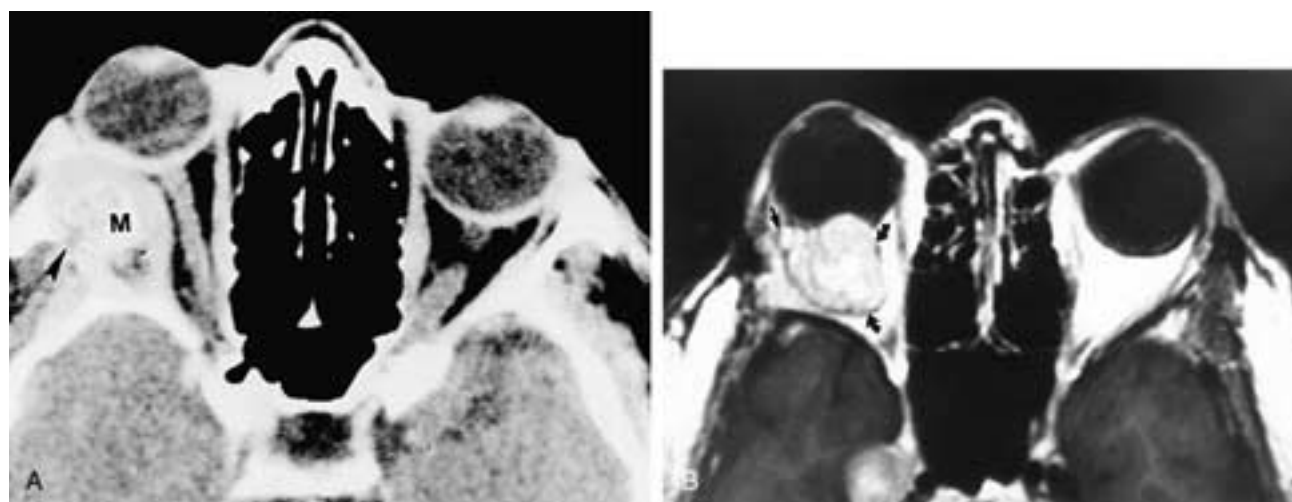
A, Hemangiopericytoma. Contrast-enhanced axial CT scan shows an enhancing mass (*M*) compatible with hemangiopericytoma. Note the erosion of the lateral orbital wall (*arrowhead*). B, Recurrent hemangiopericytoma. Enhanced axial T1-weighted MR scan shows a heterogeneously enhancing mass (*arrows*) compatible with recurrent hemangiopericytoma. (Courtesy of Dr. Michael Rothman.)
